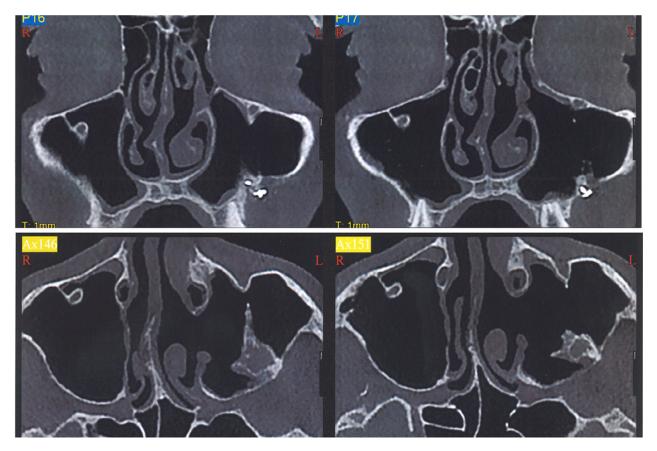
Coronal and axial computed tomography images obtained 6 months after surgery. The patient was treated with functional endoscopic sinus surgery (FESS) combined with an intraoral approach. The osteomeatal complex (OMC) is enlarged. The sinus cavity is well aerated and adequately communicating with the middle meatus. A minimal radiopacity can be seen in the posterior portion of the sinus in the axial scans.
